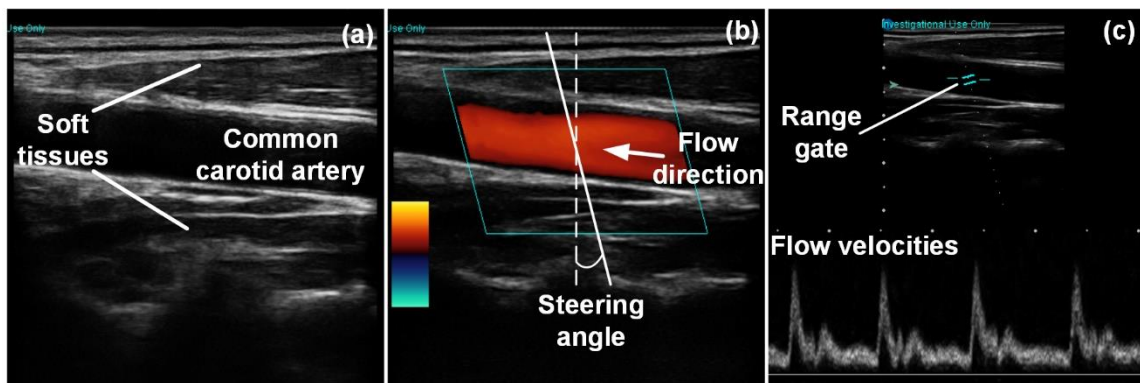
(a) A B-mode image of a segment of a common carotid artery. (b) A colour flow image. The steering angle is indicated. The colour represents the magnitude and direction of the flow (red indicates that the flow is moving towards the transducer). (c) A Doppler Spectrogram displaying the flow velocity profile measured within the range gate.
